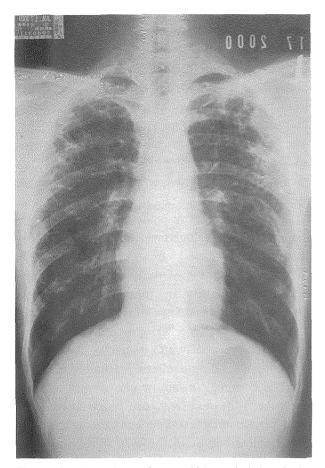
Chest X-ray image shows multiple cystic lesions in the bilateral upper lung fields, and bony destruction of the left 7^{th} rib.
